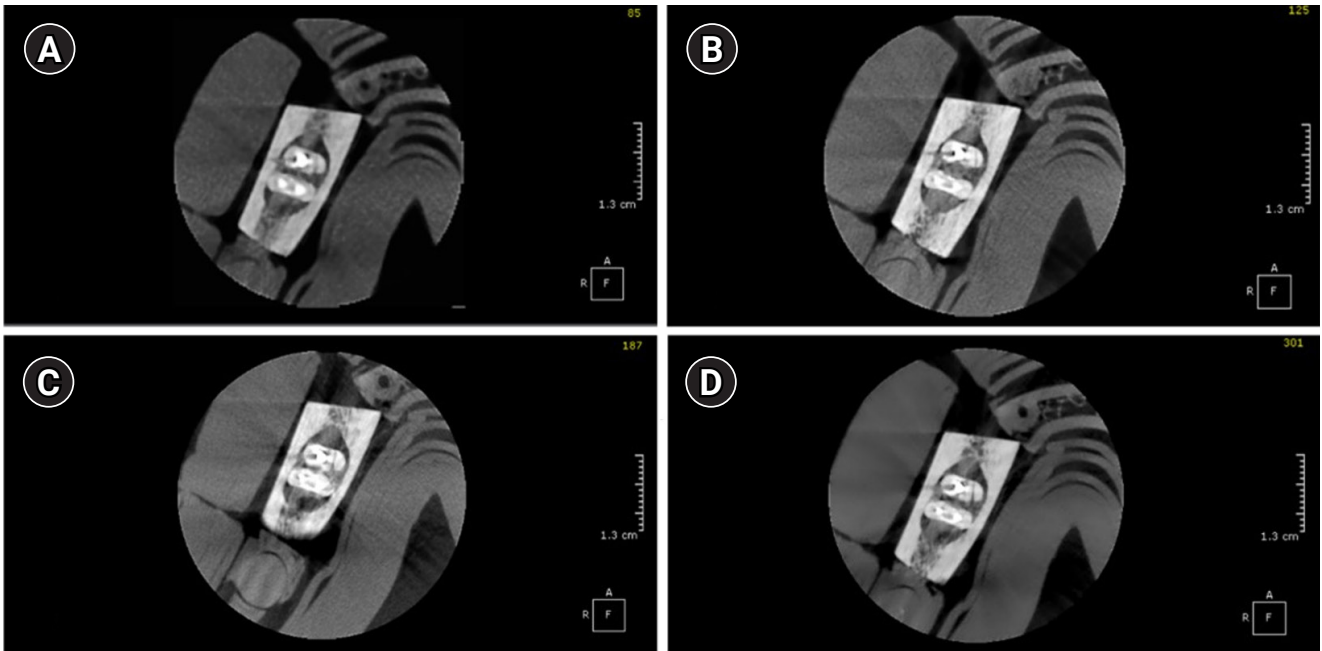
Axial cone-beam computed tomography slices of a sample tooth with post acquired on the four protocols. (A) Low dose resolution, (B) standard resolution, (C) high resolution, and (D) endo resolution.
